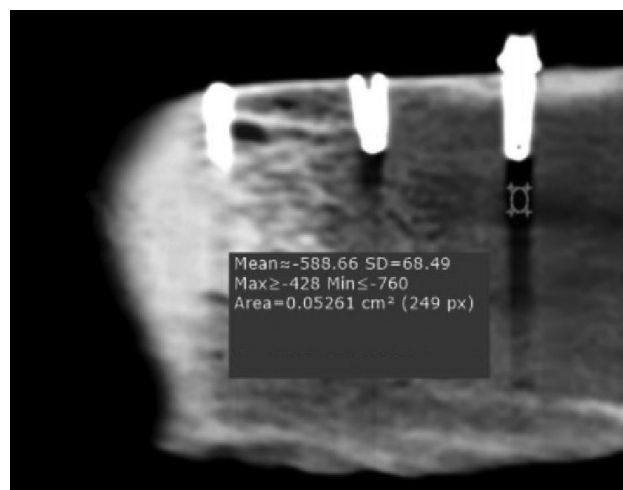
Artifact measurement on CT scan
